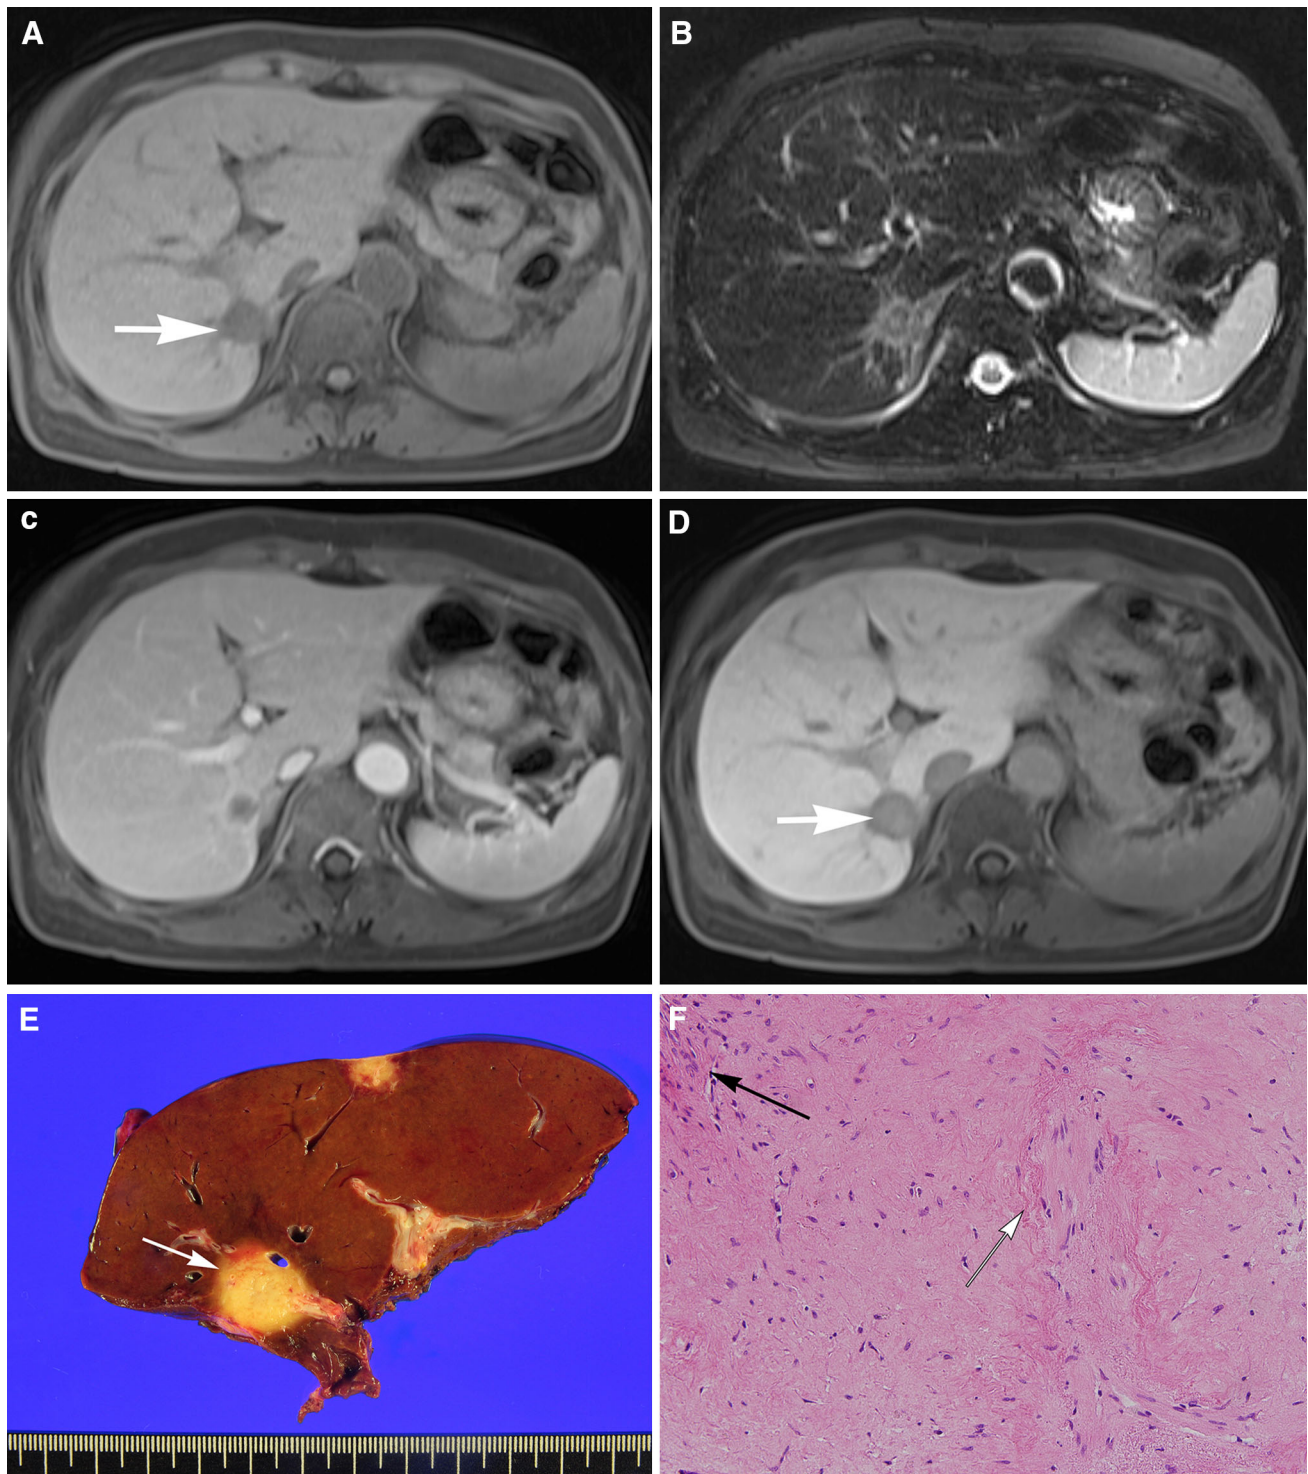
A 53-year-old female patient who underwent right hemihepatectomy. A round tumor (*arrow*) is visible in segment VII with capsular retraction (A), and has peripheral hyperintensity and central hypointensity on T2-weighted images (B). After administration of Gd-EOB-DTPA, portal venous phase image shows that the tumor is peripherally enhanced (C), and hepatobiliary phase image shows central hyperintensity (*ar-*
